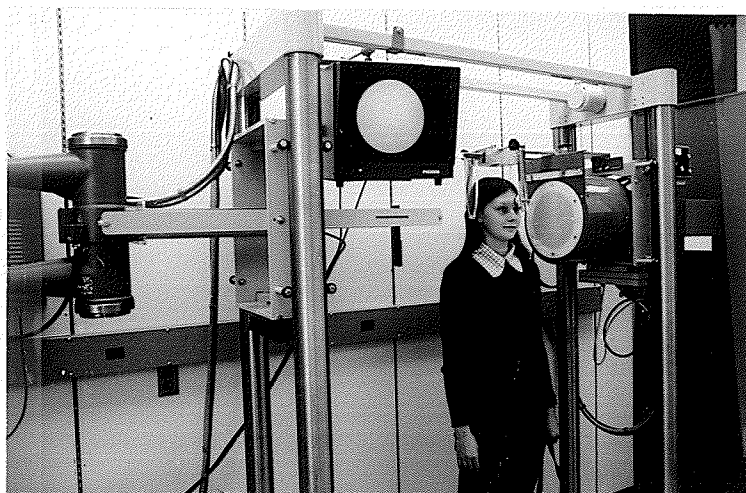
A photograph showing the positioning of a subject in the Picker radiographic fluoroscopic unit.
